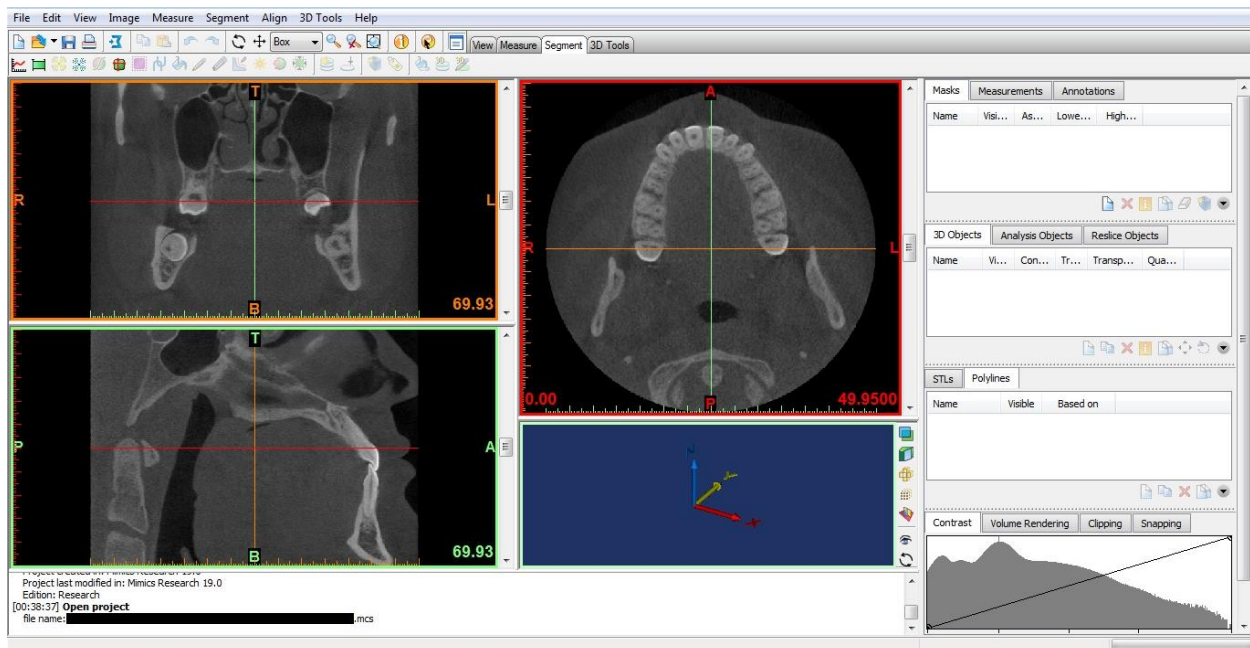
CBCT imported into Mimics from raw DICOM data
